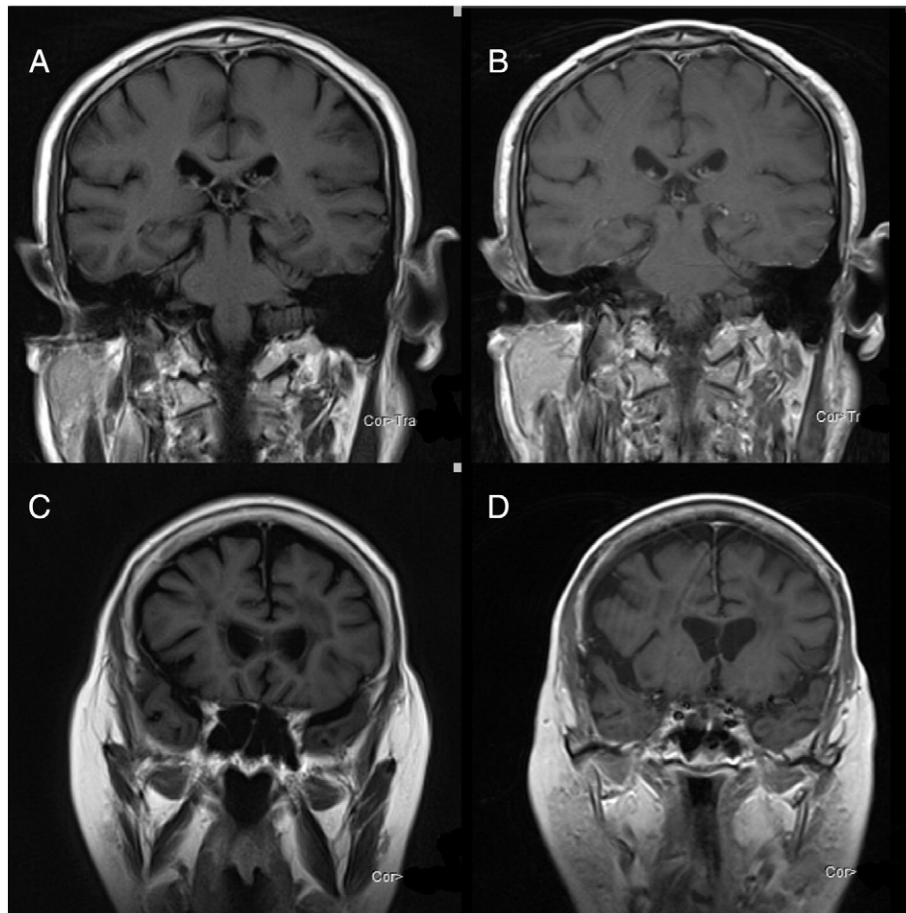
Sequences: T1W FLAIR BLADE coronal (A, C), T1W SE coronal (B, D). T1W FLAIR BLADE can better eliminate foldover artifacts and motion artifacts.
